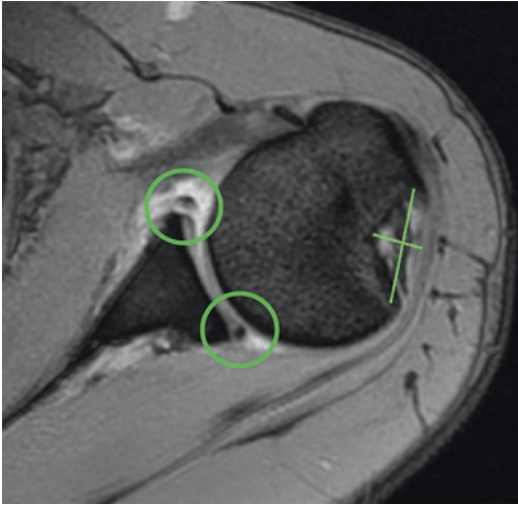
Hill–Sachs lesion and concomitant pathologies (anterior labrum lesion and posterior labrum lesion, *circles*) in magnetic resonance imaging
